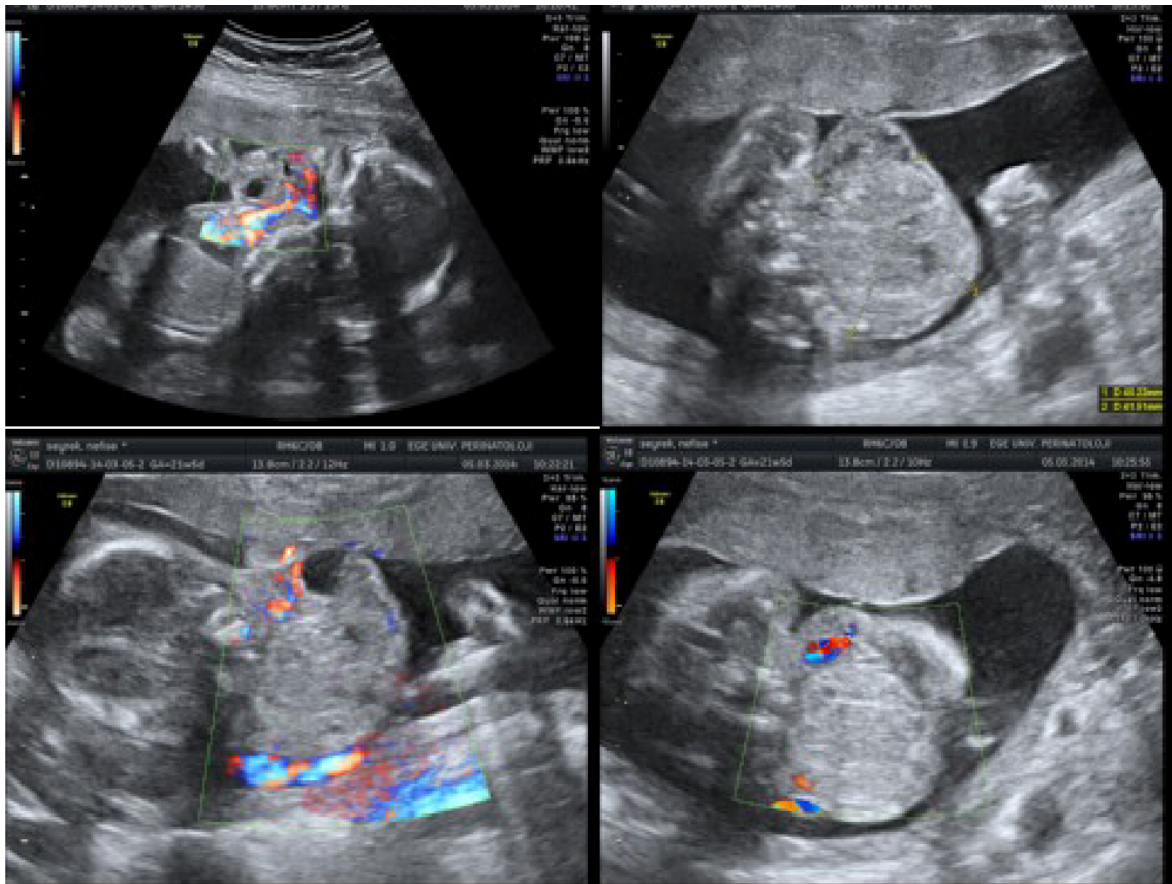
Intrauterin sonographic findings the mass was heterogenous and solid in nature with few cystic components and it was extending from the level of clavícula to brainstem.
